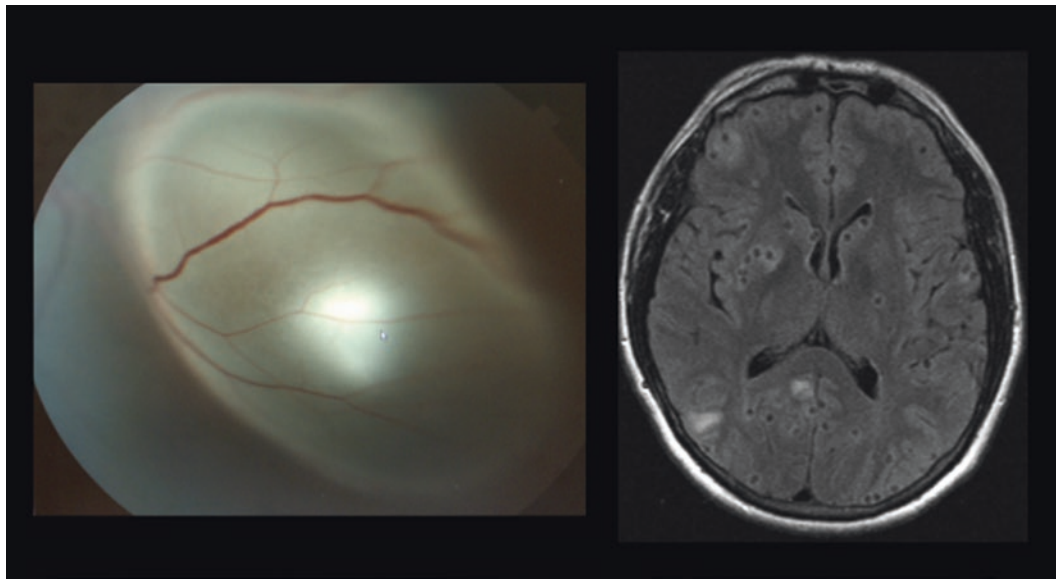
Left:* Fundus photo demonstrating subretinal cyst from cystercercosis with white scolex centrally. *Right:* axial FLAIR MRI sequence demonstrating multiple cystic lesions in the brain due to neurocystercercosis
